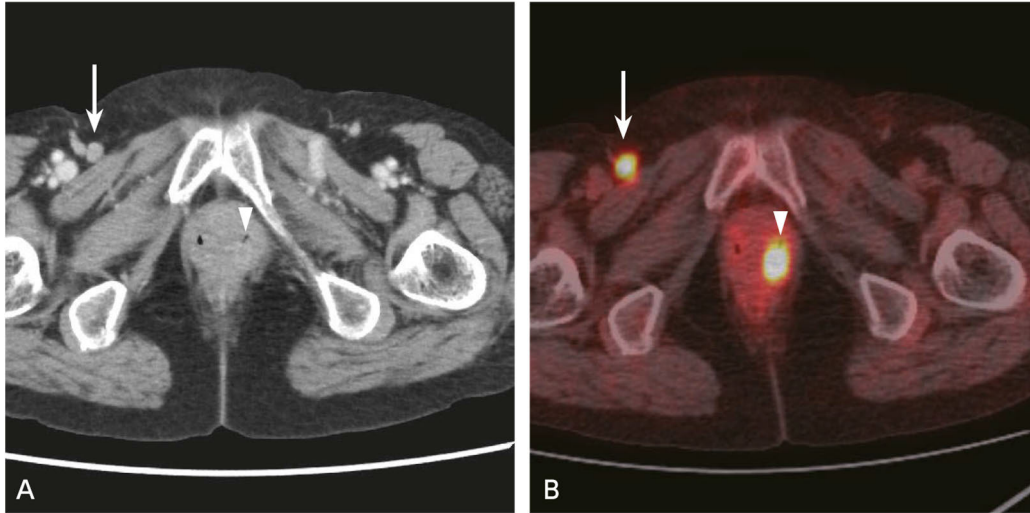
Figure A postoperative case of endometrial cancer where FDG-PET/CT shows a nodal metastasis and local recurrence, for which contrast-enhanced CT provided inconclusive findings.
